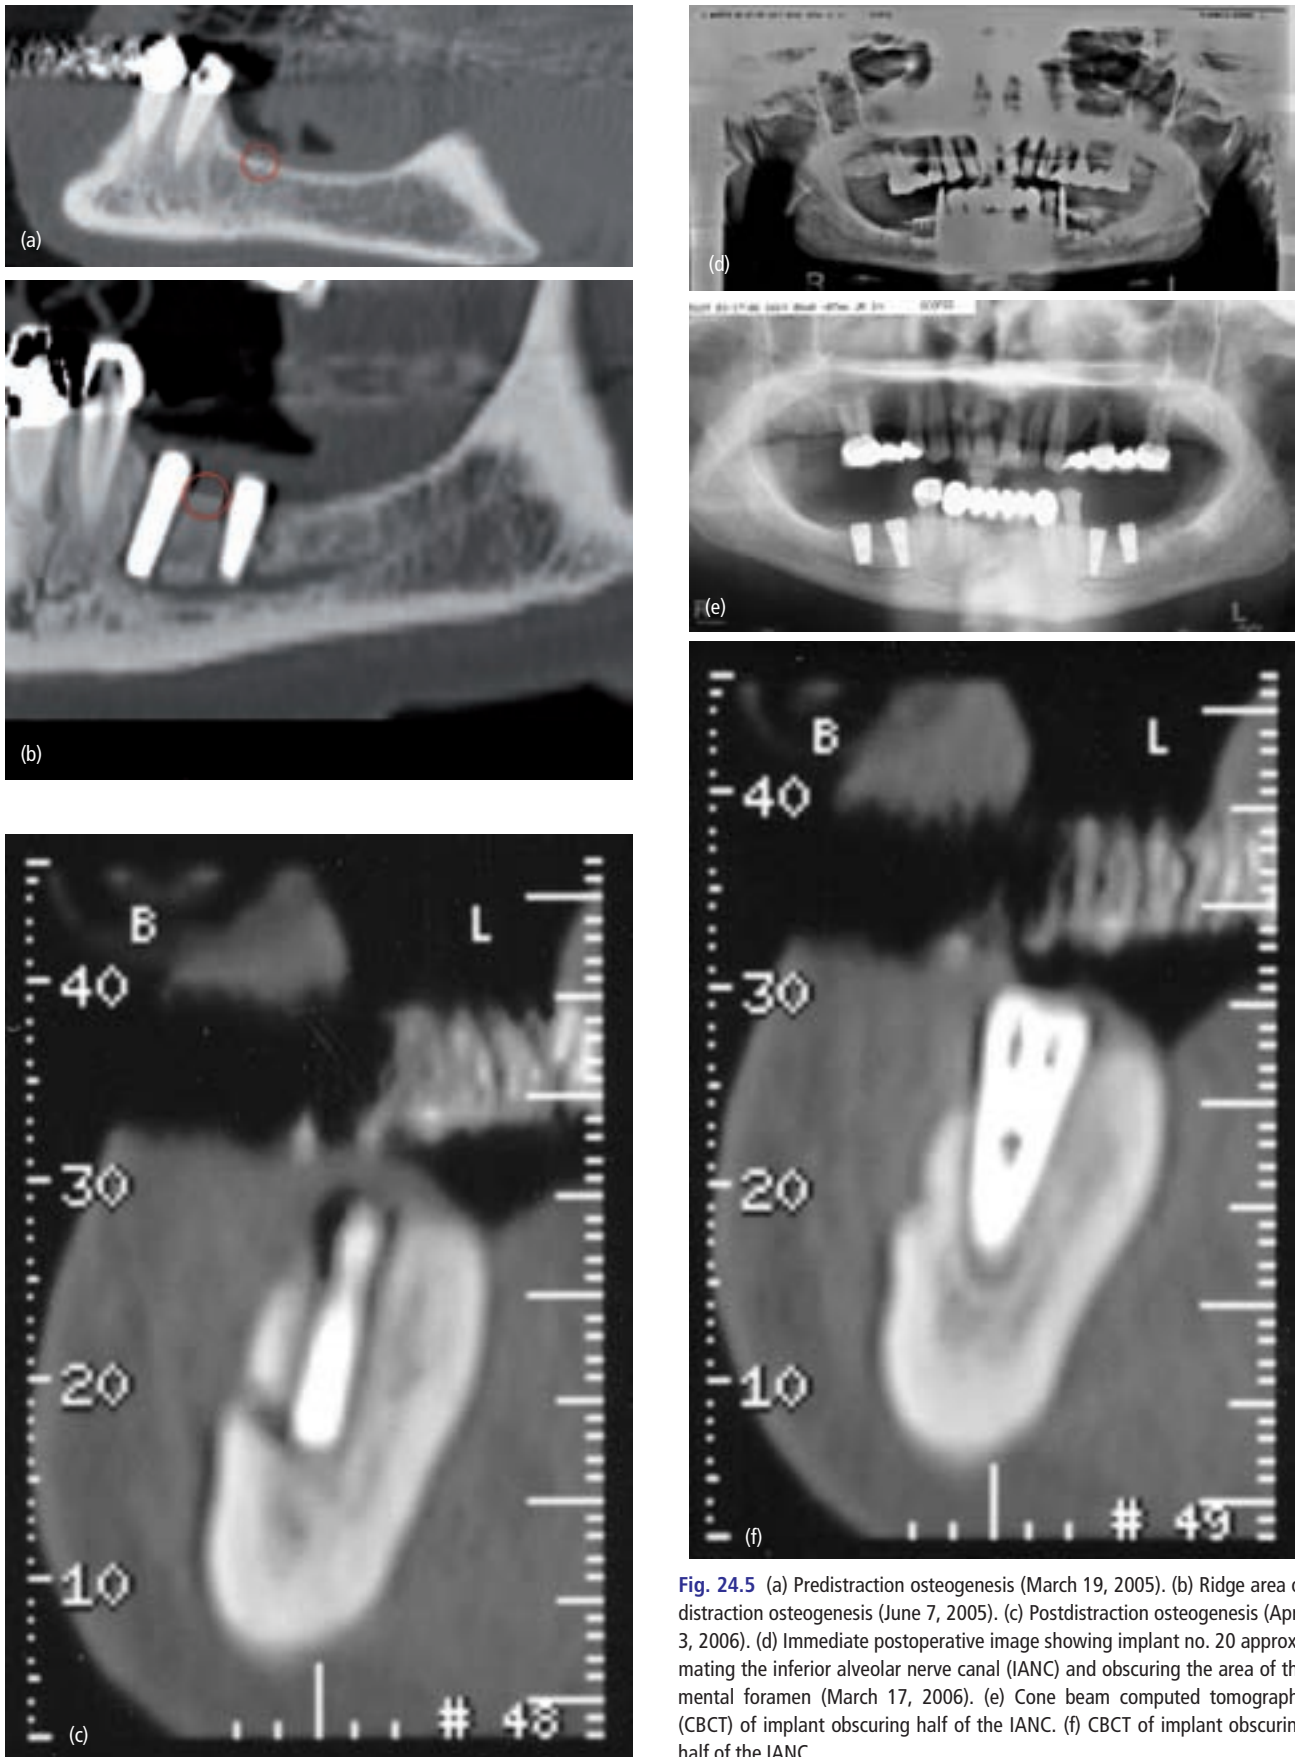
(a) Predistracted osteogenesis (March 19, 2005). (b) Ridge area of distraction osteogenesis (June 7, 2005). (c) Postdistracted osteogenesis (April 3, 2006). (d) Immediate postoperative image showing implant no. 20 approximating the inferior alveolar nerve canal (IANC) and obscuring the area of the mental foramen (March 17, 2006). (e) Cone beam computed tomography (CBCT) of implant obscuring half of the IANC. (f) CBCT of implant obscuring half of the IANC.
